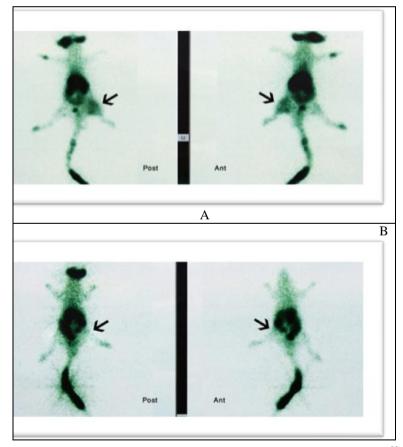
Scintigraphy imaging study has performed two hours after the 37 MBq ^{99m}Tc-Ciprofloxacin injected intravenously due to contra lateral tail vein. The scintigraphy imaging study has been performed with ^{99m} Tc-Ciprofloxacin radiotracer 168 hours after inoculation of S aureus A: susceptible to ciprofloxacin B: resistant to ciprofloxacin respectively. The images were shown posterior (Post) and anterior (Ant) views of infected foots.
